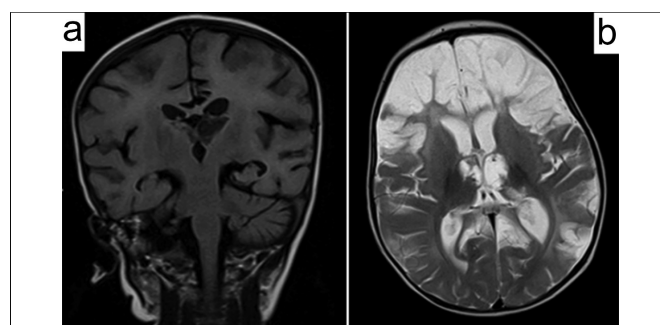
MRI brain findings of the same infant with ANE after 20 days. Abnormal T1 curvilinear hyperintensities showing laminar necrosis with significant gyral enhancement (a); Abnormal T2 hyperintensities completely involving bilateral frontal lobes, left parieto-occipital, right occipital lobes, anteromedial portion of both thalami and corpus callosum (b).
